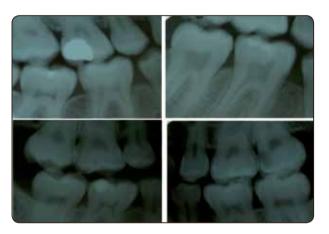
Bite-wing radiographs showing three different cases with marginal bone loss of posterior teeth.
